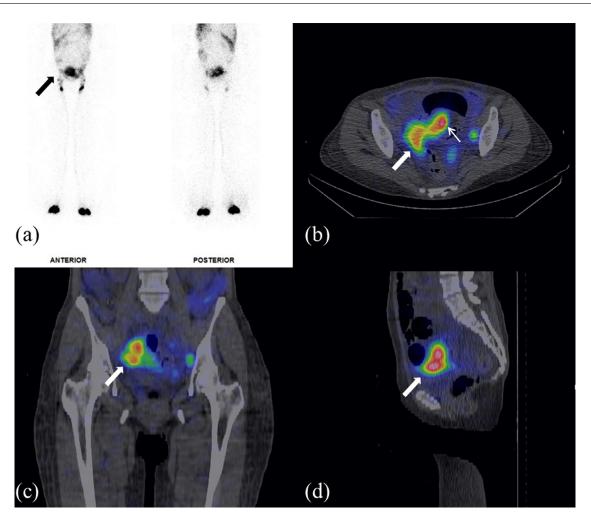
Planar image of lymphoscintigraphy amd multiplanar reconstruction of SPECT/CT. (A) Ninety minutes after the injection, showing the reduced number of inguinal lymph nodes accumulating the isotope bilaterally and abnormal extranodal isotope distribution in the pelvis (black arrow). Fusion axial (B), coronal (C), and sagittal (D) SPECT/CT images of the pelvis demonstrate the extranodal hotspot in the pelvic cavity on the right side, 2 cm above the superior margin of the femoral head (thick white arrow). On axial imaging, another hotspot is observed in the midline pelvic cavity (narrow white arrow). SPECT/CT: Single-photon emission computerized tomography/computed tomography.
